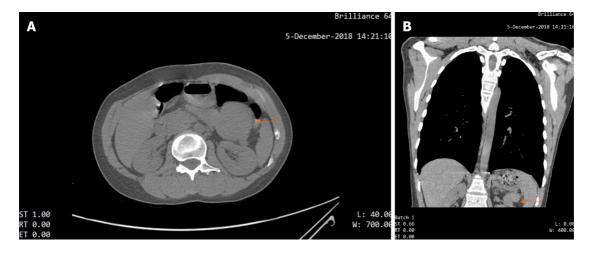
Computed tomography scan showed that there was an iso-dense, well-circumscribed mass (orange arrow) in the upper abdominal area. A: Axial section; B: Coronal section.
